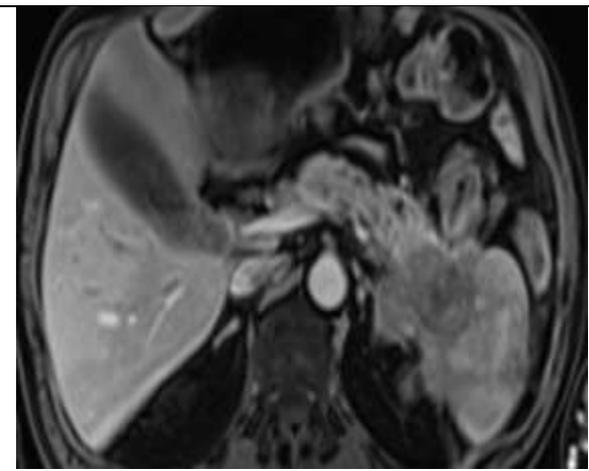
CE MRI of upper abdomen: Axial plane: Pancreas tail neoplasm with infiltration of spleen and liver metastases.
